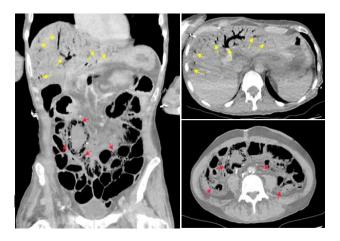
CT abdomen showing pneumatosis intestinalis (red arrowheads) and gas within the portal system (yellow arrowheads) during the third admission with NOMI.
